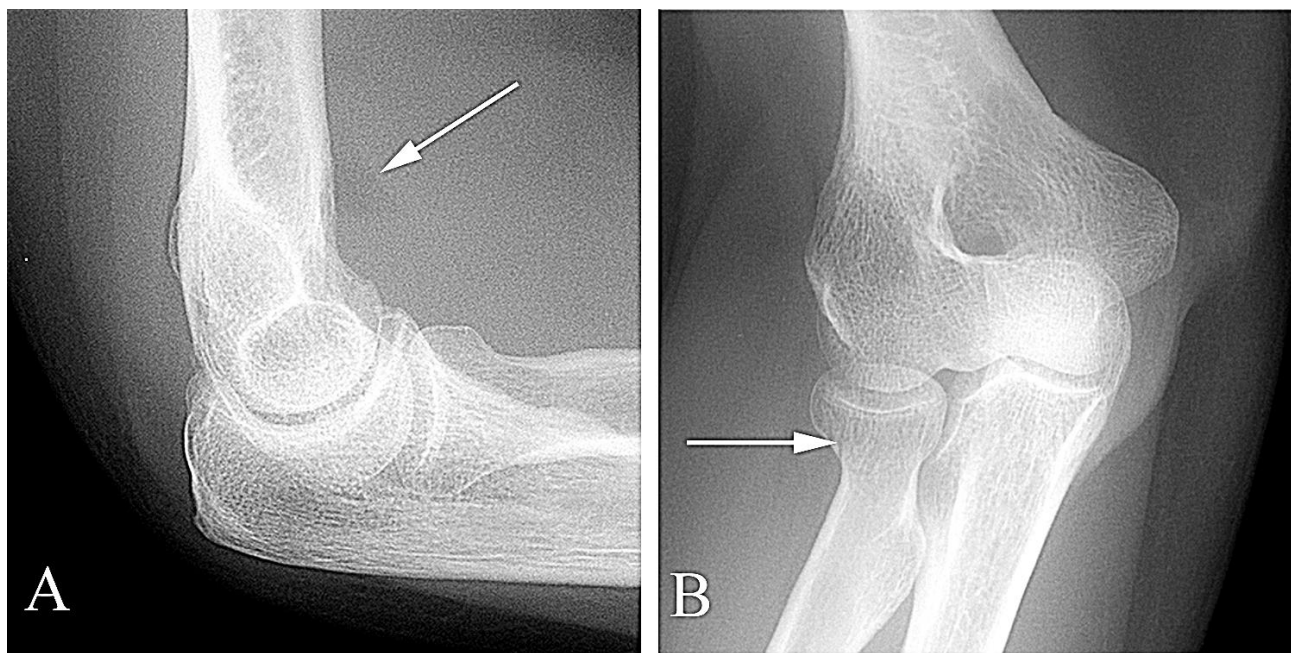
Radial fracture in a 51 year old woman who had pain following trauma. A. Lateral plain film of the elbow shows displacement of the fat pad from the anterior aspect of the distal humerus (arrow). B. Oblique plain film shows a subtle fracture through the radial neck (arrow). Elbow effusions following trauma are typically secondary to marrow and hemorrhage in the joint from a fracture.
